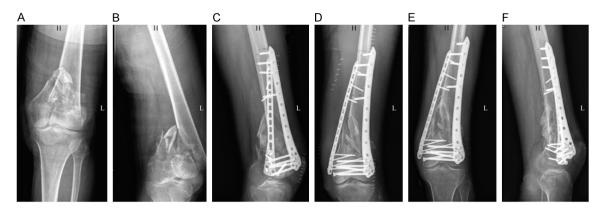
Male, 64 years, car accident, AO-Type: 33C2. A, B: Normal and lateral X-ray images of knee joint; C, D: LLP+MAP after surgery; E, F: Fracture healing 1 year after surgery.
